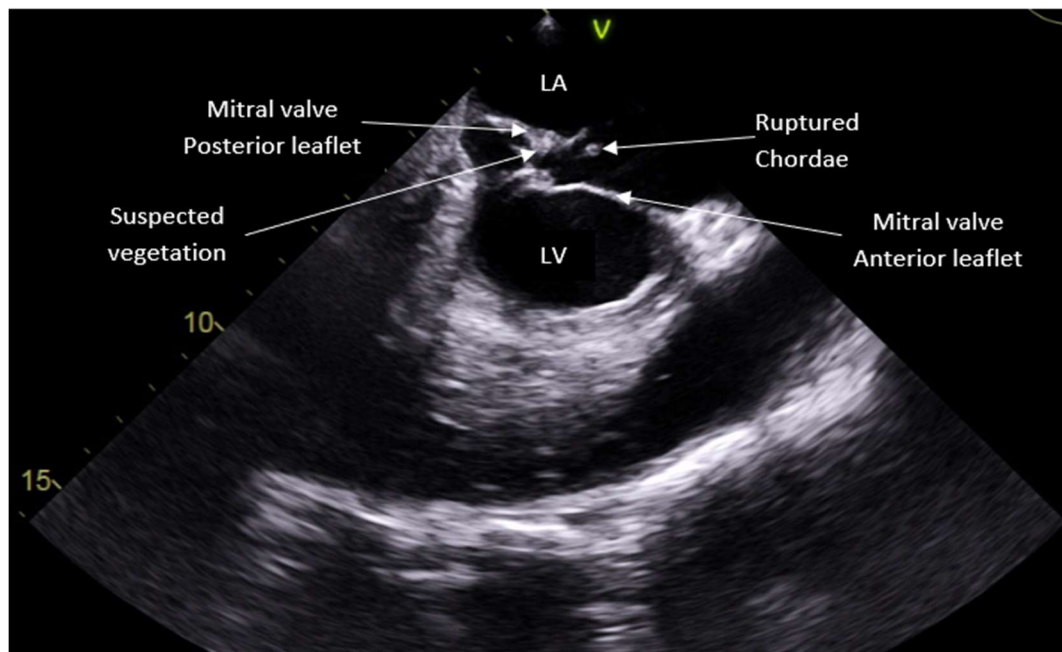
Transesophageal echocardiogram demonstrating mitral valve vegetation and ruptured chordae.
